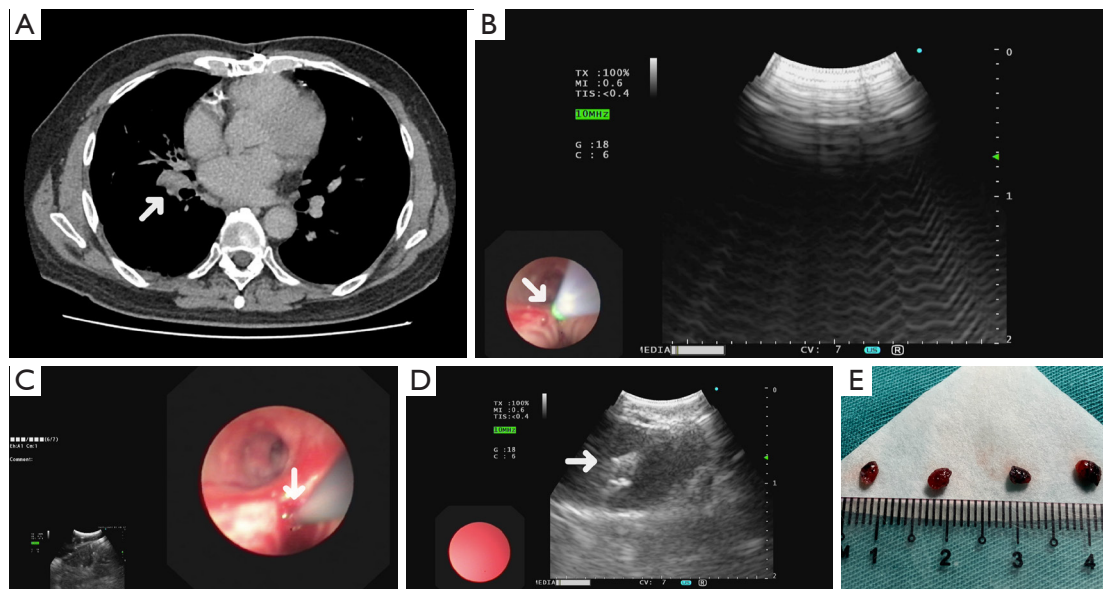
Right hilar lymph node. CT chest axial view showing enlarged right hilar lymph node (arrow, A). EBUS evaluation revealed an enlarged station 11Ri lymph node. The initial TBNA procedure was performed, and subsequently, the track was dilated with an electrocautery needle knife at the secondary carina (arrow, B), which caused interference with the ultrasound image during electrocautery activation. The 1.1 mm cryoprobe was then carefully placed through the mucosa defect and track (arrow, C). The tip of the cryoprobe is clearly visualized throughout the insertion process to prevent overshooting of the target (arrow, D). With four cryobiopsy passes, a good tissue sample of excellent size was obtained from the lymph node (E). CT, computerized tomography; EBUS, endobronchial ultrasound; TBNA, transbronchial needle aspiration.
